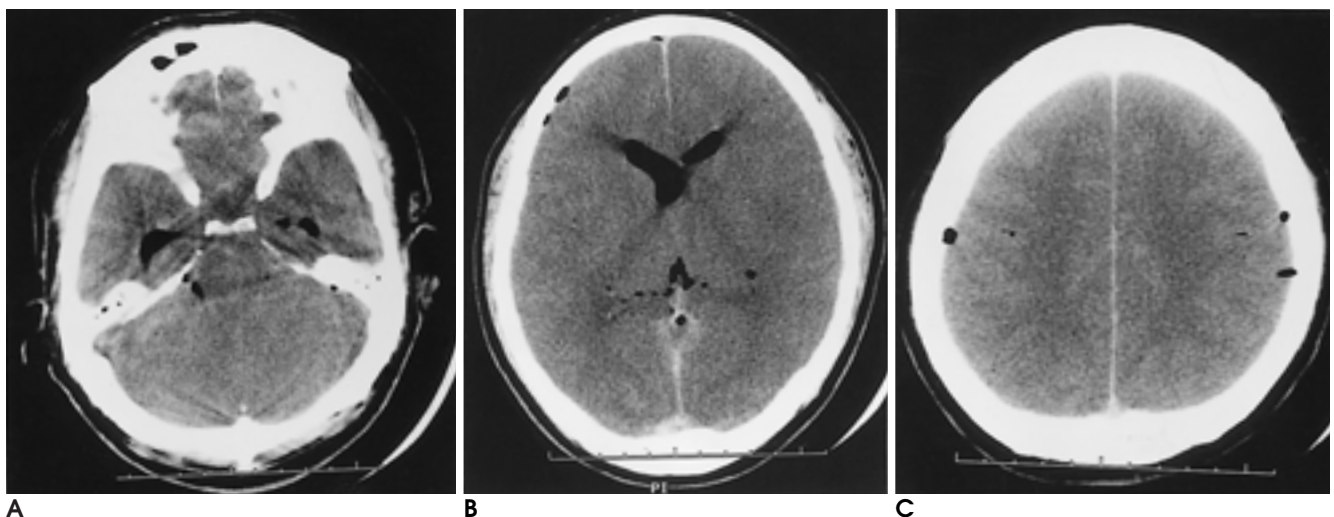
Precontrast Brain CT scan of pneumocephalus from gas-forming bacterial infection.
